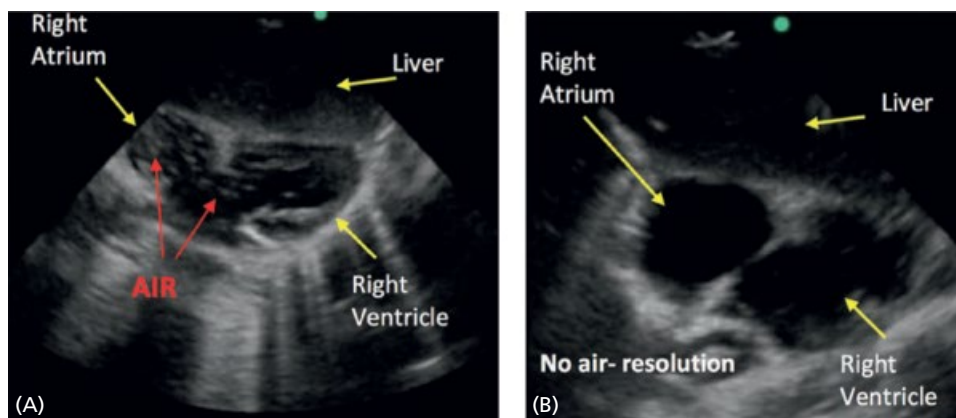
Intracardiac air embolus diagnosed by portable transthoracic echocardiography in a patient with hypoplastic left heart syndrome in the cardiac catheterization laboratory. (A) Subxiphoid view of systemic right ventricle and common atrium with intracardiac air (red arrows). (B) Resolution of intracardiac air. Source: Reproduced from Adler [253] with permission of Wolters Kluwer.
